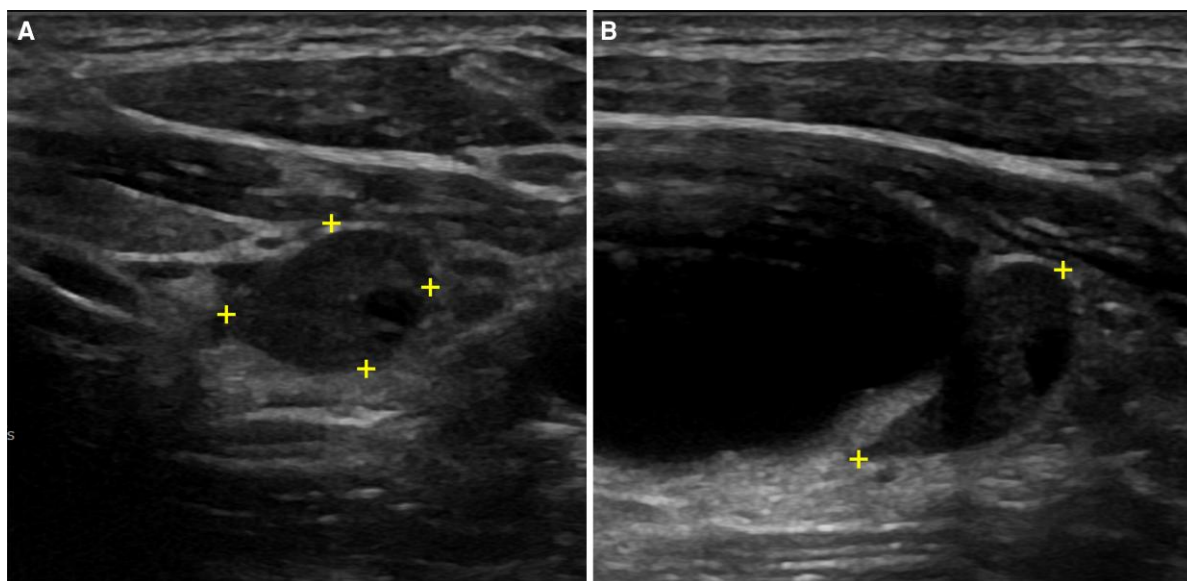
Thyroid ultrasound in transverse plane (A) and sagittal plane (B) showing an 8 mm x 11 mm x 14 mm solid-appearing lower pole nodule of the left lobe without suspicious malignant features suggestive of a possible parathyroid adenoma.
